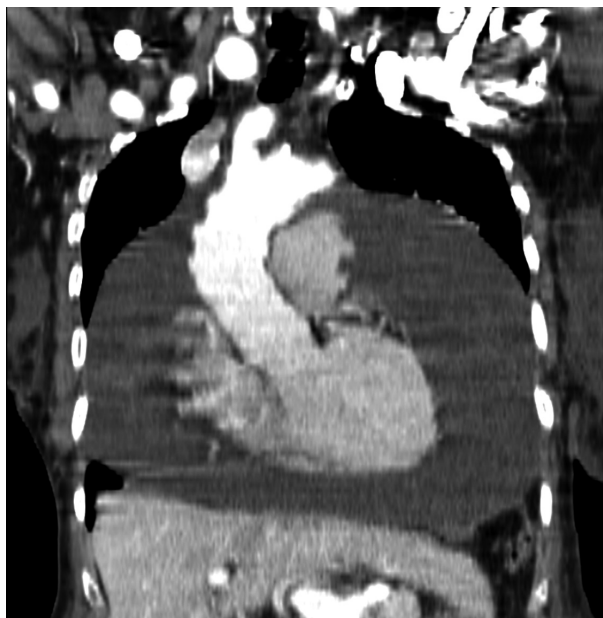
Coronal computed tomographic slice of the thorax obtained in a mediastinal window confirming the large pericardial effusion.
